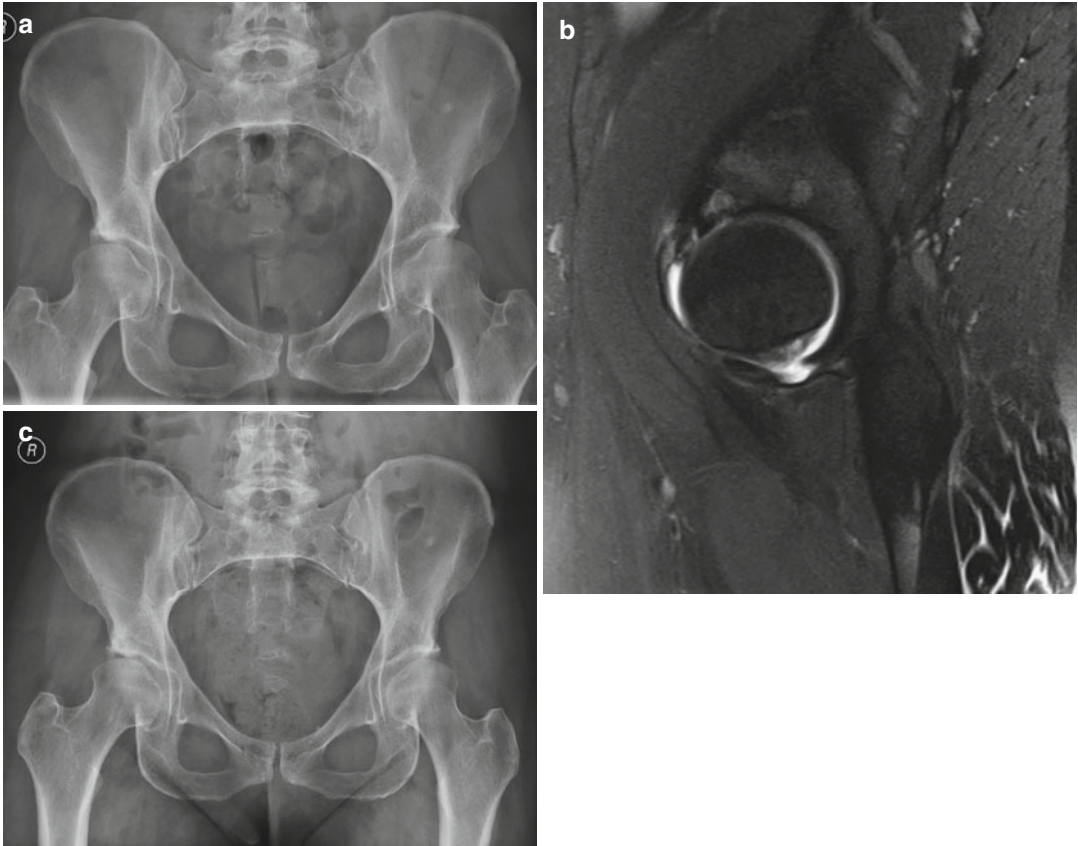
(a) Pre-op pelvis radiograph showing acetabular dysplasia. (b) Pre-op sagittal MRA of the right hip showing an anterosuperior labral tear as well as
